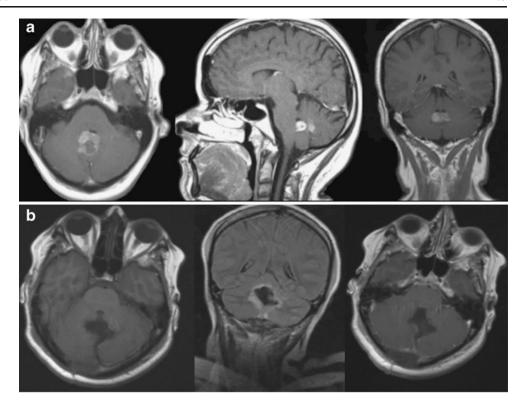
a Preoperative MRI scan (from left to right): T1 postcontrast medium, axial sequence: bilateral lesion accentuated on nodulus and uvula vermis; T1 postcontrast medium, sagittal sequence showing the medial and vermal zone infiltration; T1 postcontrast medium, coronar sequence: bilateral nuclei fastigii and dentatus lesion. b Postoperative MRI scan of the second patient (from left to right): T1 sequence showing the iatrogenic lesion of vermis, FLAIR coronar sequence: possible temporal affection of bilateral nuclei dentatus due to postoperative edema; T1 postcontrast medium, axial sequence: absence of enhancement
